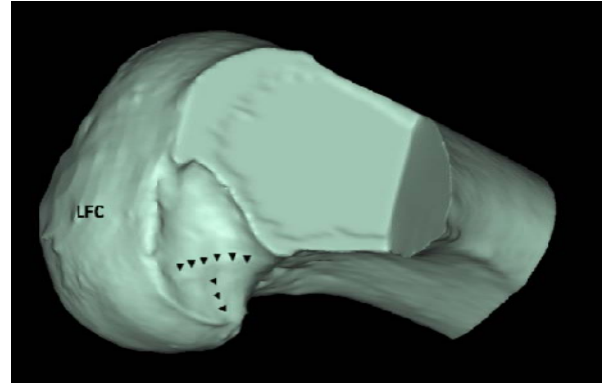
3-Dimensionally reconstructed CT-scan of the right femur of a subject without ACL injury. Both the lateral intercondylar ridge and the lateral bifurcate ridge can be identified.
